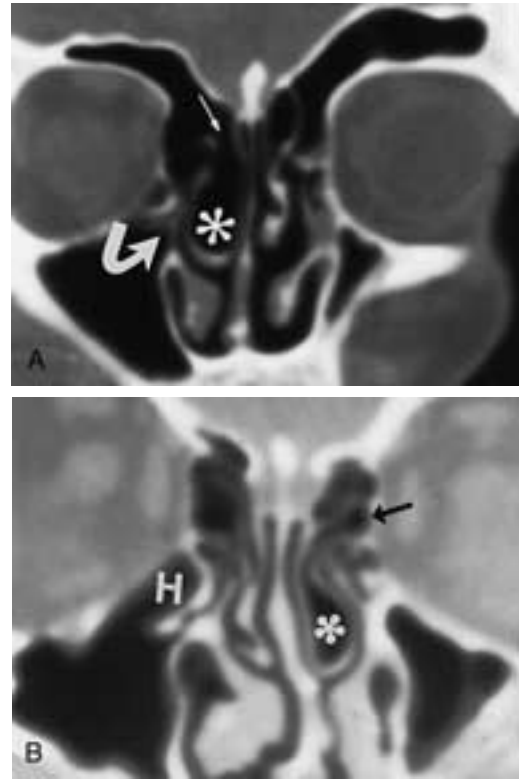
Concha bullosa in two different patients. A, Coronal CT image demonstrates a prominent right concha bullosa (*asterisk*) with communication to the frontal recess (*small arrow*). Note the obstruction of the right middle meatus (*curved arrow*). B, Coronal CT image demonstrates a left-sided concha bullosa (*asterisk*) with communication to the sinus lateralis (*small arrow*). Note the contralateral Haller (infraorbital ethmoid) cell (*H*).
